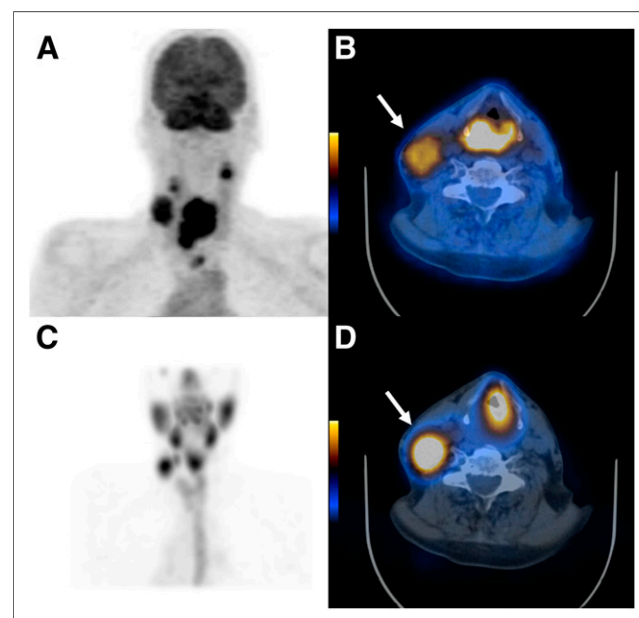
Results from a 67-y-old man with large hypopharyngeal carcinoma. Maximum-intensity-projection PET image (A) and axial fused PET/CT image (B) 45 min after injection of 355 MBq of ^{18}F -FDG and maximum-intensity-projection SPECT image (C) and axial fused SPECT/CT image (D) 4 h after injection of 503 MBq of $^{99\text{m}}\text{Tc}$ -PAMA-cobalamin. $^{99\text{m}}\text{Tc}$ -PAMA-cobalamin uptake was more intense in right cervical lymph node metastasis than ^{18}F -FDG uptake (arrow, B vs. D). Mean relative tracer accumulation in different organs in relation to whole-body scan were liver, 54%; left kidney, 2%; lungs, 4%; and tumor, 3%.
